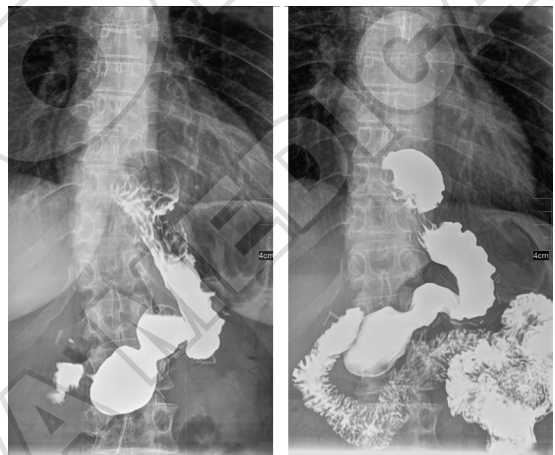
Intrathoracic sleeve migration (>2 cm) seen on postoperative contrast X-ray studies with barium, in GERD recurrent, symptomatic patient with previously LSG and simple posterior cruroplasty, defined as failure of the cruroplasty.
